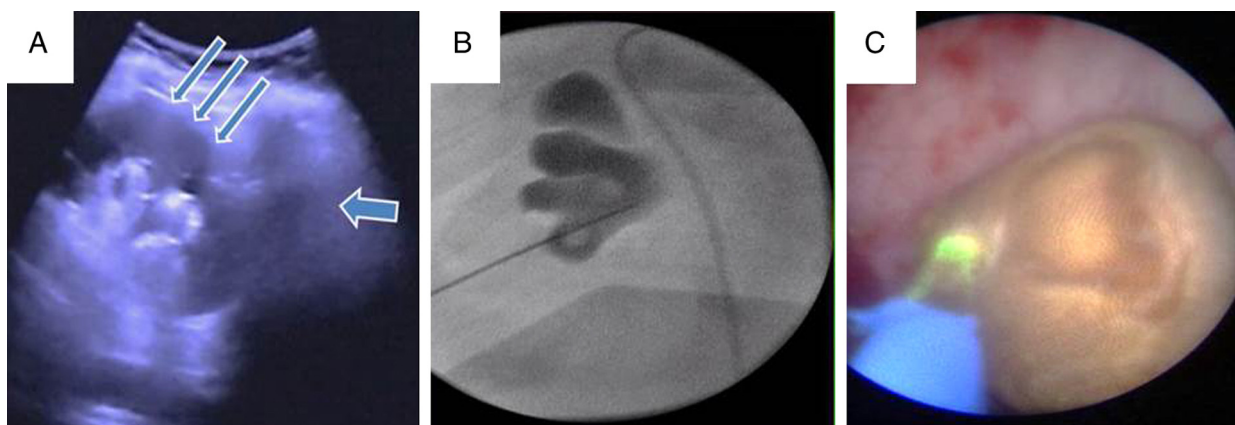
(A) Renal ultrasound image during puncture access (small arrows: renal cortex outline, large arrows: bowel loops in close proximity). (B) Fluoroscopic guided puncture. (C) Endoscopic view (Mini PCNL) during laser lithotripsy of the calculus.
